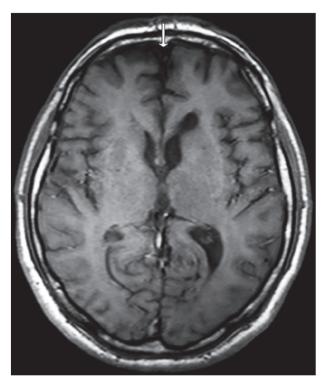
T1 weighted brain magnetic resonance image (MRI) transverse image showing frontal lobe atrophy (arrow).
